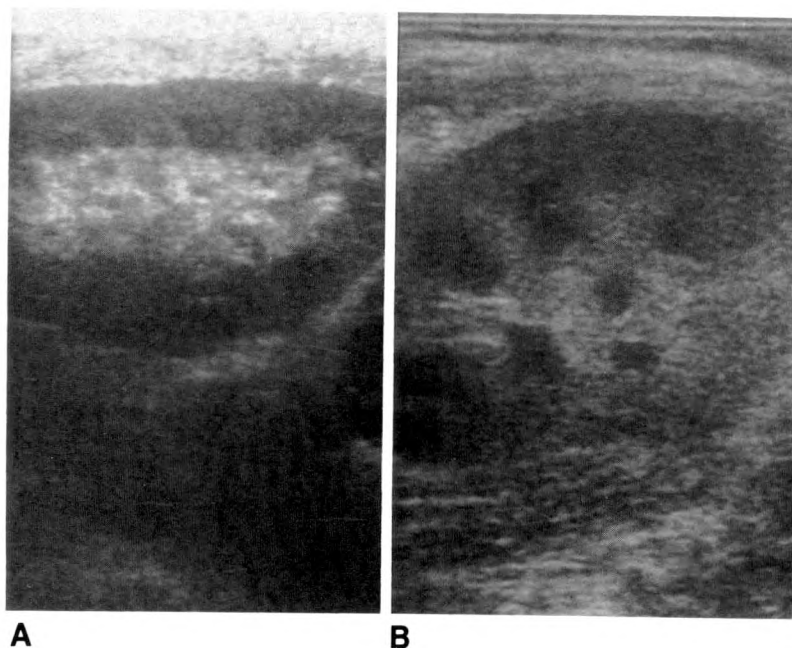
A, Longitudinal sonogram of patient interpreted as having a normal allograft but in whom biopsy showed severe rejection.
